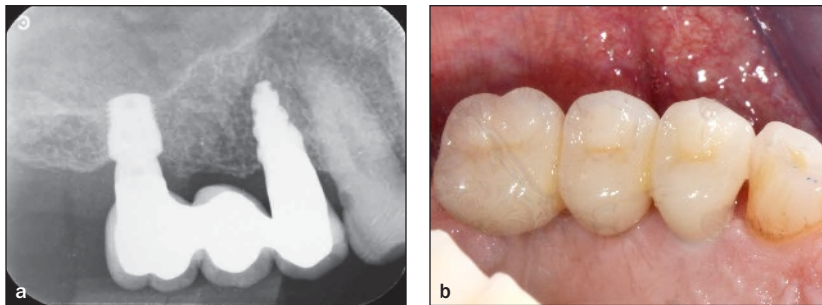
(a) 12 months postoperative radiograph and (b) clinical palatal view of patient no. 5.
